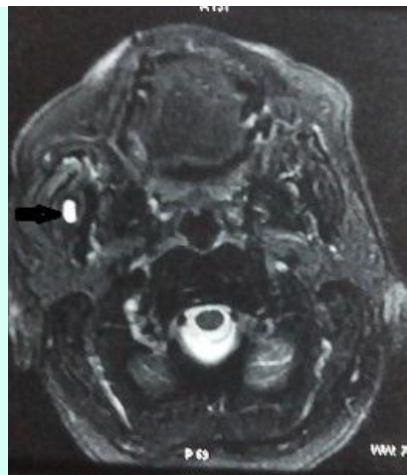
MRI showing intra cystic tiny eccentric hypointense nidus
